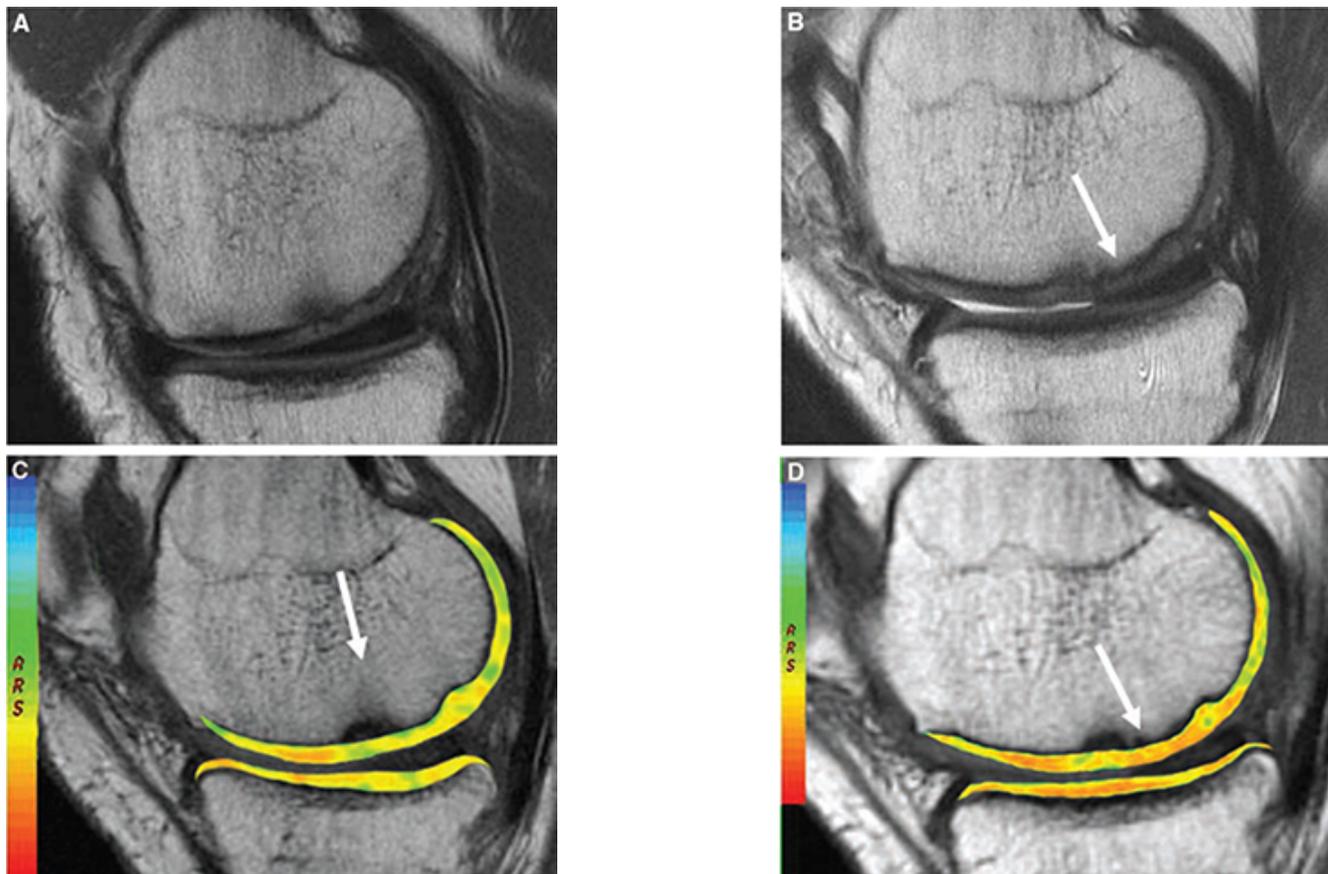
A, Sagittal magnetic resonance images after implantation of a NeoCart patch over the medial femoral condyle. Cartilage-sensitive magnetic resonance image at 1 year demonstrates fill of the defect by repair tissue that is hyperintense relative to native cartilage. B, Good fill was maintained at 2 years, with progressive decrease in signal intensity of the repair cartilage (arrow) undergoing “maturation.” C, Corresponding T2 mapping at 1 year demonstrates prolongation of T2 values at the site of cartilage repair (arrow). D, Corresponding T2 mapping at 2 years demonstrates partial stratification of T2 values (arrow).
